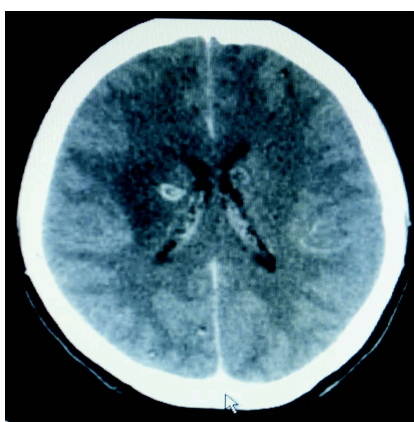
CT scan picture post treatment during follow up visit after 3 months showing decrease in size of largest lesion measuring 6×6 mm and decrease in number of cysts.
